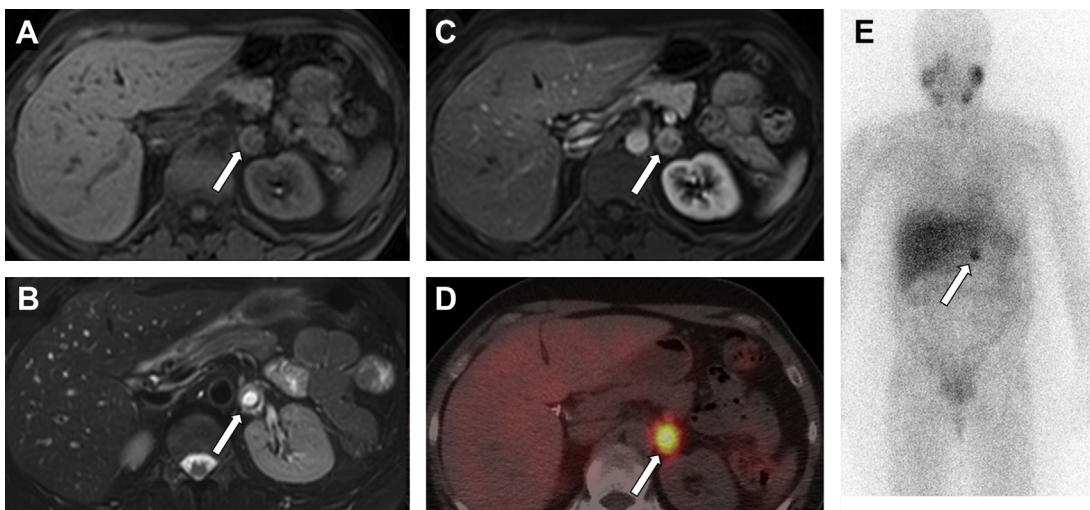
Axial MR imaging with T1-weighted precontrast (A), arterial phase postcontrast (B), and T2-weighted (C) images demonstrate a T2 hyperintense enhancing left adrenal mass (arrows), which demonstrated marked activity of both SPECT/CT (D) and planar (E) images from subsequent [¹²³I]MIBG scan, confirming the diagnosis of pheochromocytoma.
